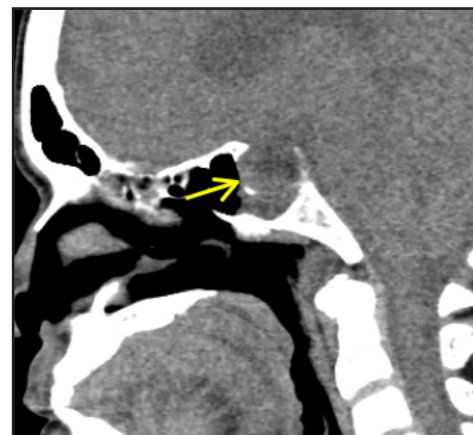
Cranial CT scan with contrast, midsagittal view. There is absence of bone on the sphenoid roof (arrow).
